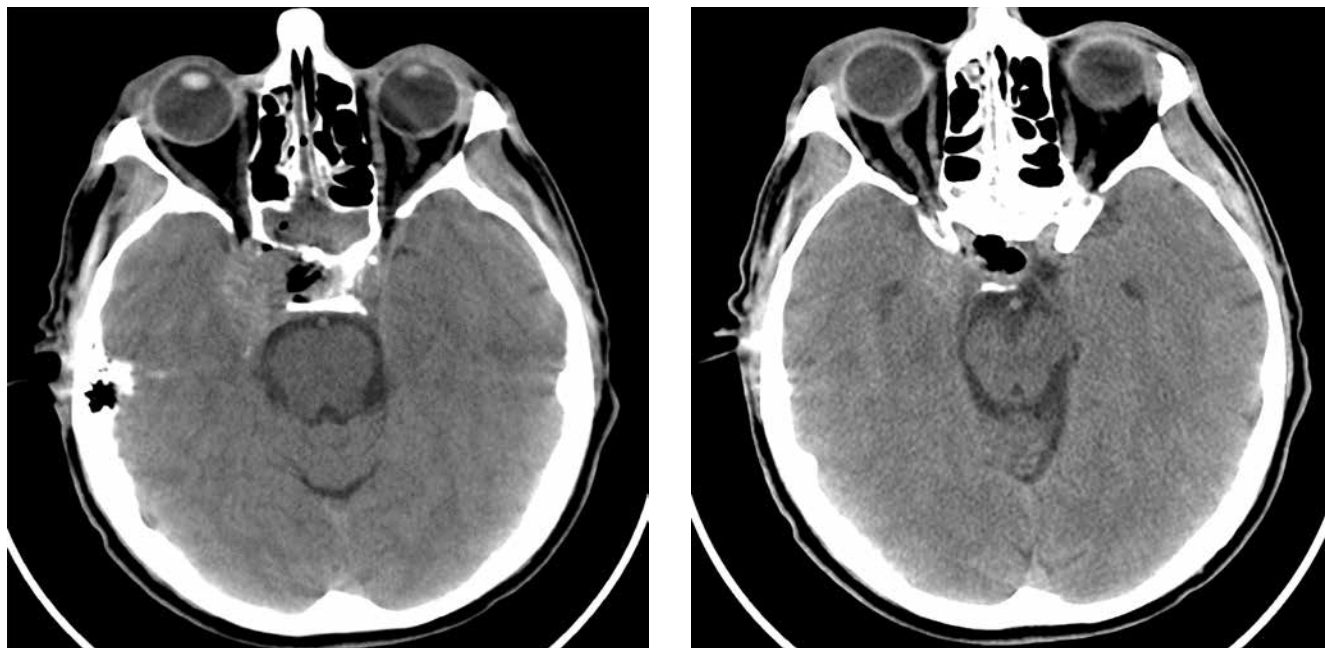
Computed tomography of patient S. immediately after surgery. Partial resection of the lesion
